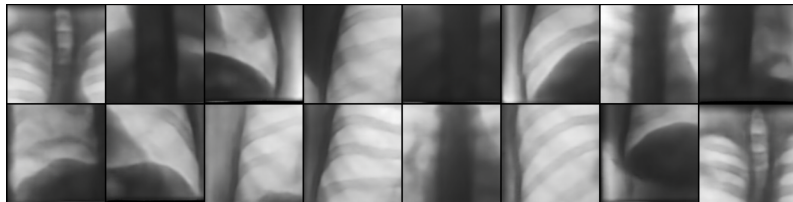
Example of generated chest x-ray slices
